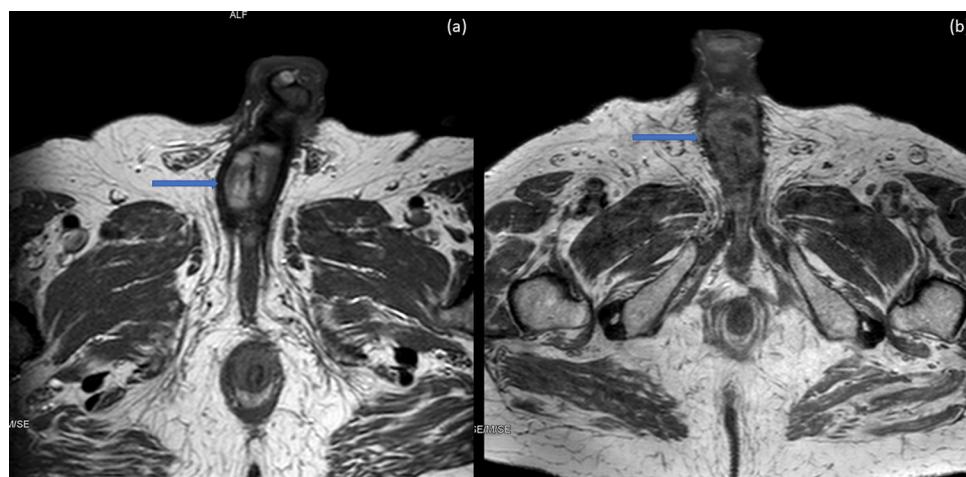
MRI, axial view showing a penile metastasis in a patient with prostatic adenocarcinoma (case 1).
